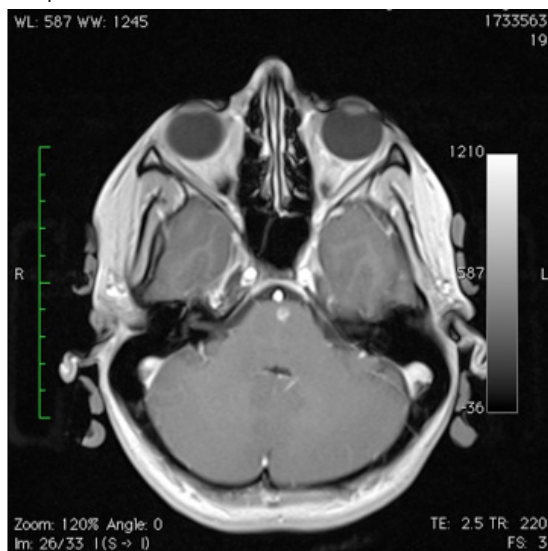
Magnetic resonance imaging of a horizontal section of the pons and cerebellum. A small bleed is present the left paramedian anterior region of the brainstem.
